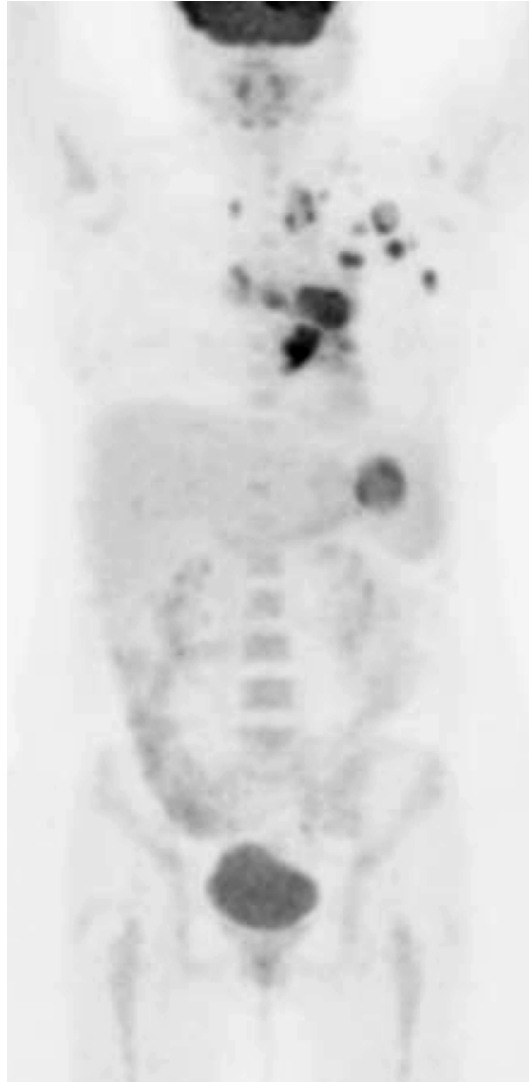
Primary staging with PET/CT revealed additional disease sites (right supraclavicular, left axillary, and splenic hilar nodes)
